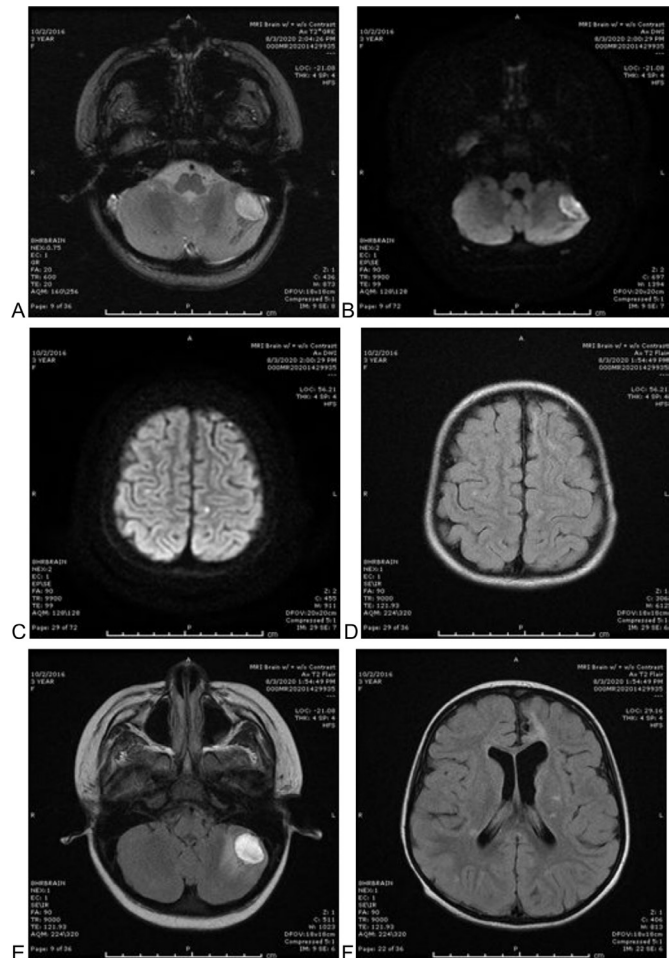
Neuroimaging findings. (A) Axial GRE sequence demonstrating left cerebellar hemisphere haemorrhagic conversion. (B) Axial DWI sequence demonstrating restricted diffusion in the left cerebellum consistent with cerebrovascular accident (CVA). (C) Axial T2 FLAIR sequence demonstrating signal prolongation in multiple anterior vascular distributions. (D) Axial DWI sequence demonstrating restricted diffusion in distal cortical areas consistent with embolic stroke. (E) Axial T2 FLAIR sequence demonstrating signal prolongation along cerebellar infarction. (F) Axial T2 FLAIR sequence demonstrating signal prolongation along the periventricular zones. Of note, there is limited oedema surrounding the areas of thromboembolic infarct, aside from the left cerebellar hemisphere, likely due to evidence of haemorrhagic conversion and subsequent vasogenic oedema. DWI, diffusion weighted imaging; FLAIR, fluid-attenuated inversion recovery; GRE, gradient recalled echo.
